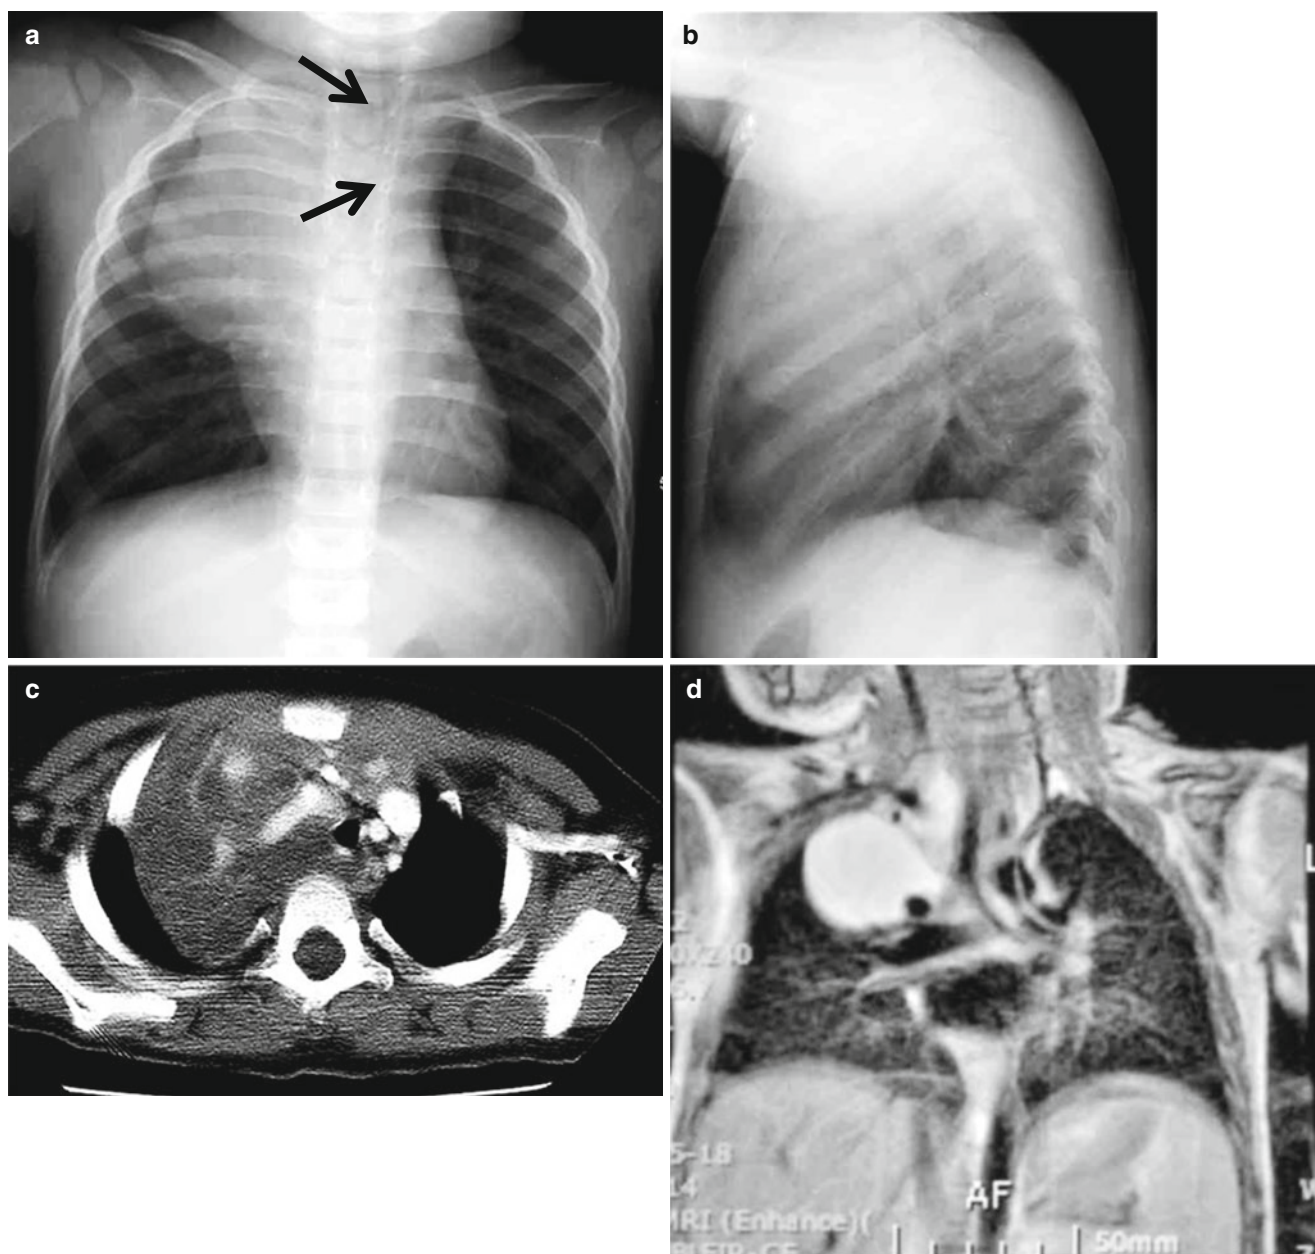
Lymphangioma in a 15-month-old boy (Case courtesy of Hye-Kyung Yoon, MD). (a, b) Frontal and lateral radiographs show a rounded, lobulated anterior mediastinal structure with displacing the trachea to the left (*arrows*). (c) Contrast-enhanced CT shows a near-water
